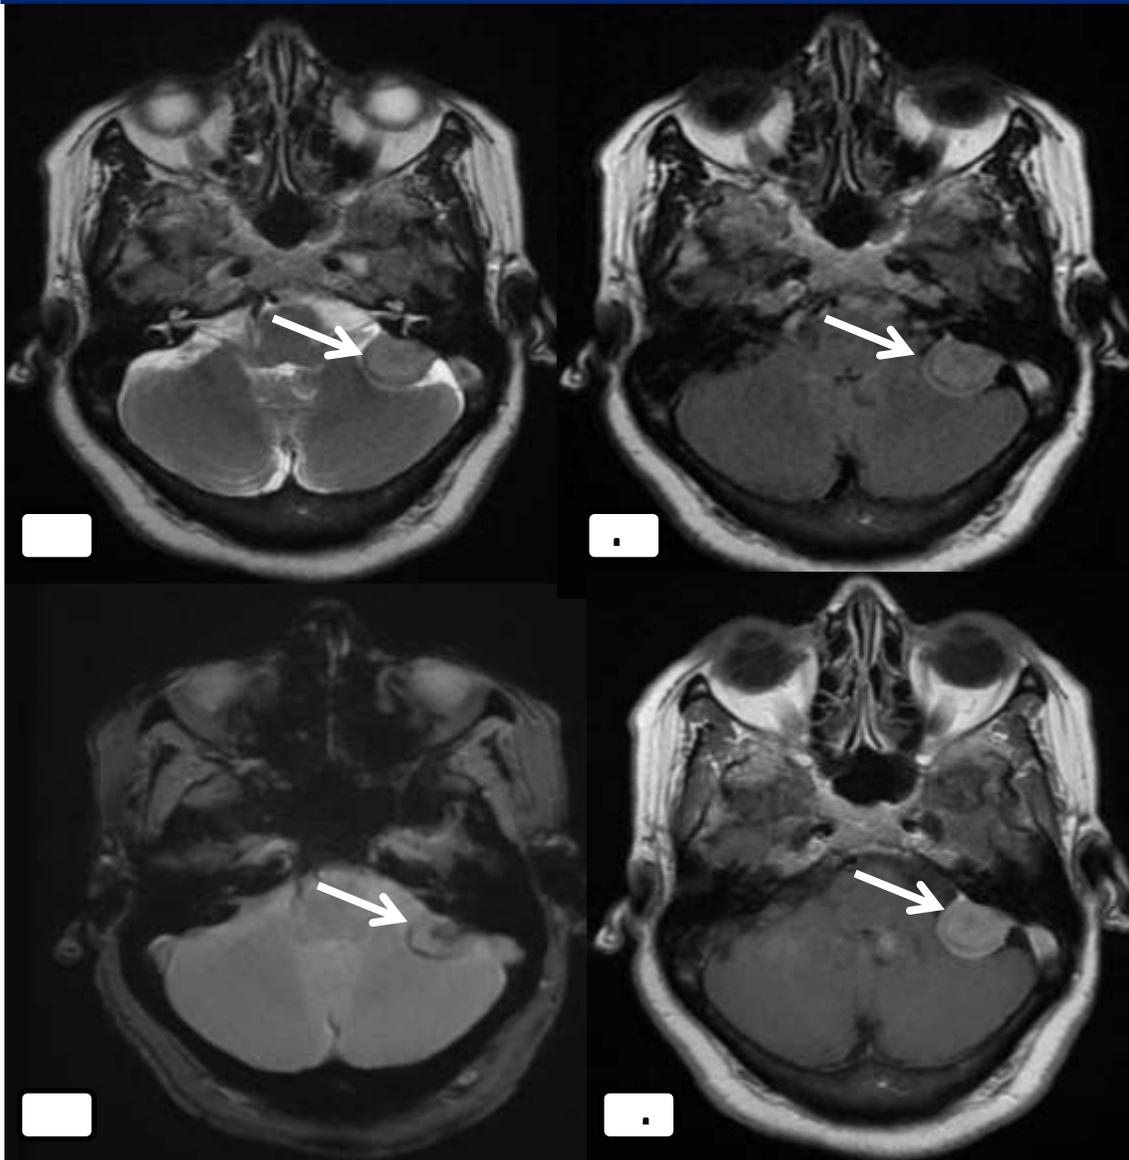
MRI in axial section in T2 sequences (a); in FLAIR sequence (b); in T2* sequence (c) and in injected T1 sequence(d): Extra-axial lesional process flush with the left CPA, broad-based implantation, well circumscribed, discrete hyper T2 and FLAIR, homogeneously enhanced intense and early after contrast, surrounded by a collar in hypo T2* signal related to calcifications, measuring 20x21mm. It exerts a discrete mass effect on the homolateral cerebellar parenchyma and determines a contact with the sigmoid sinus without invasion of the latter →Meningioma
